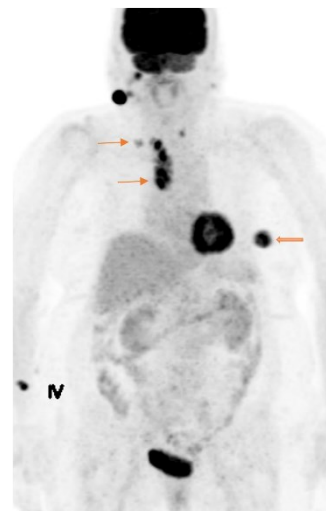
The maximum intensity projection (MIP) image of [¹⁸F]FDG PET/CT. A hypermetabolic left breast tumor is observed (thick arrow), and the uptake in the left axillary lymph node is barely noticeable. In contrast, hypermetabolic lymph nodes are observed in the right supraclavicular area and mediastinum (thin arrow). Hypermetabolic lesions are also found in both the parotid areas and the left thyroid lobe
